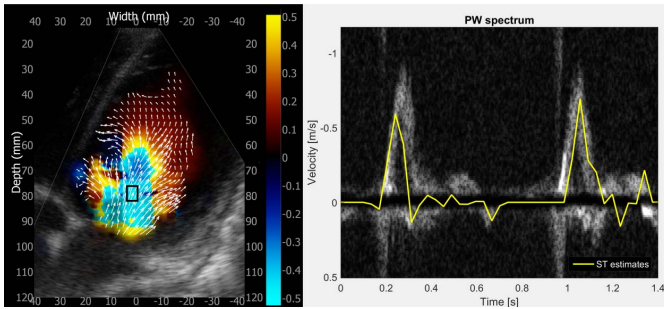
Validation of ST estimates. Left: vector flow map overlaid color flow image of the left ventricle of patient 2 (DCM). Right: PW Doppler spectrum acquired from a separate recording. Yellow line: ST velocity trace from a corresponding ROI (black square in the left image). The ST velocities have been projected on to the PW acquisition beam for comparison.
